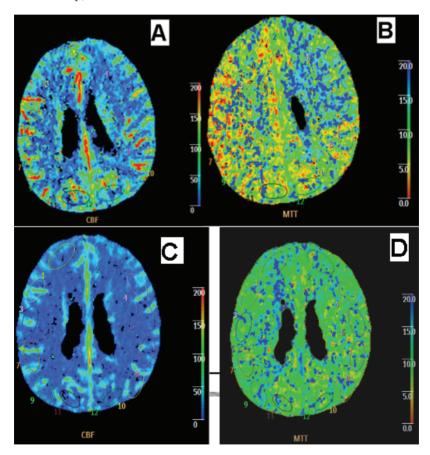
CT perfusion showing hypo perfusion in left MCA distribution (A and B) and resolution on follow up after procedure (C and D).
